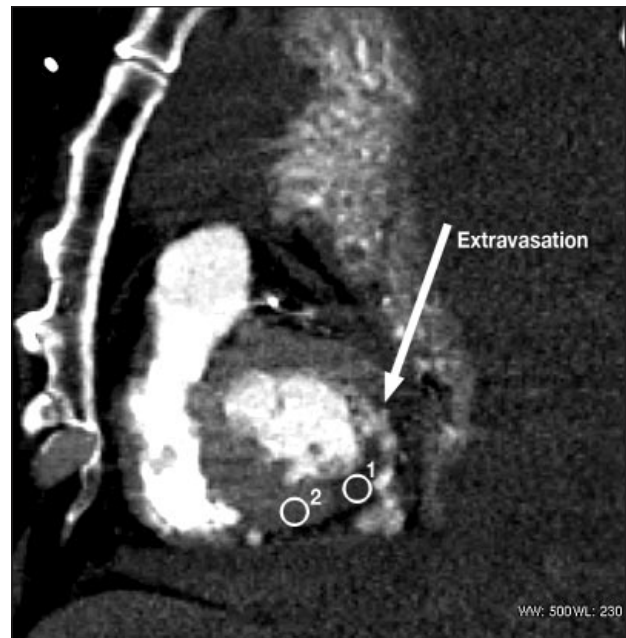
Computed tomography — left anterior oblique reconstructed image. Active contrast extravasation (arrow) is noted at the posterior wall of the left ventricle. Area 1 shows decreased enhancement (HU ~61.9), representing the area of myocardial infarction. Area 2 shows normal myocardial enhancement (HU ~120.0).
